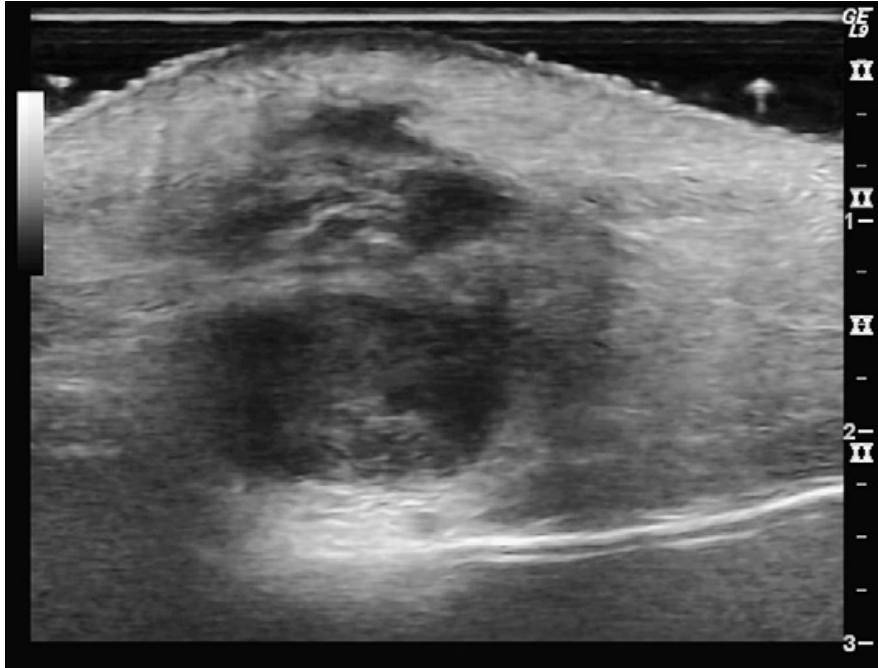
Longitudinal sonogram of parotid on an adult. Big lesion inside the parenchyma badly delimitate with heteroechoic aspect mimic a tumor: tuberculosis. (Philips Katz et al.)
